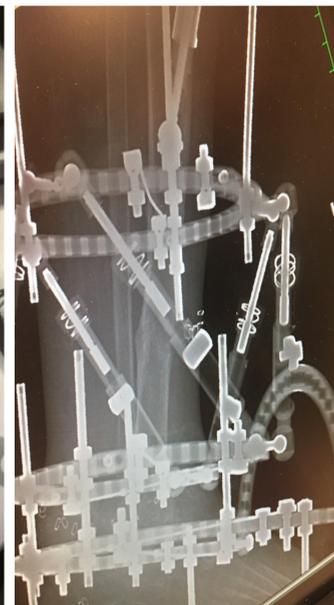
Patient B, Final X-ray
